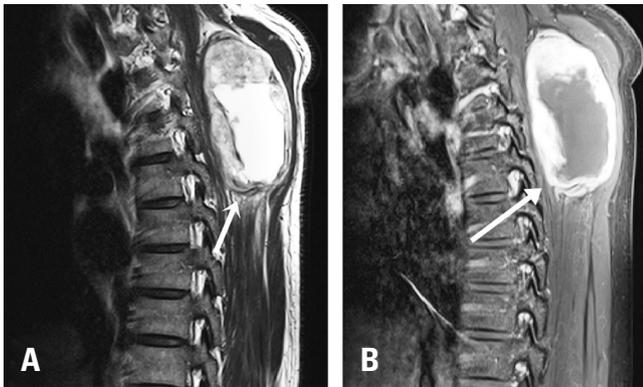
Magnetic resonance imaging showing (A) a well-defined, irregular thick-walled cystic lesion and (B) central non-enhancement with peripheral irregular heterogeneous enhancement.
